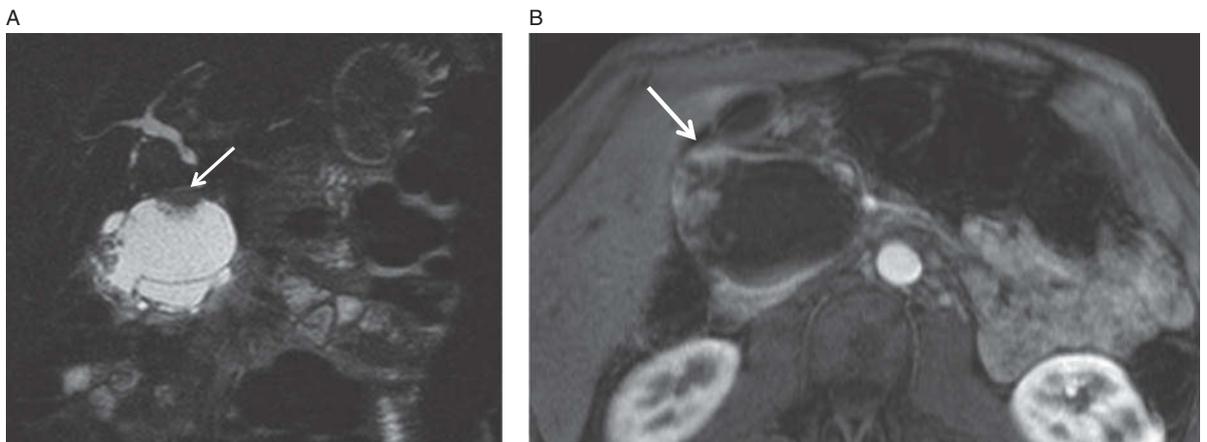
Mucinous cystadenocarcinoma. Coronal T2-weighted image (A) demonstrates a macrocystic lesion in the pancreas with internal septations and nodularity (arrow). Axial T1-weighted, fat-saturated post-contrast image (B) again demonstrates the cystic lesion with enhancing, peripheral nodularity (arrow).
